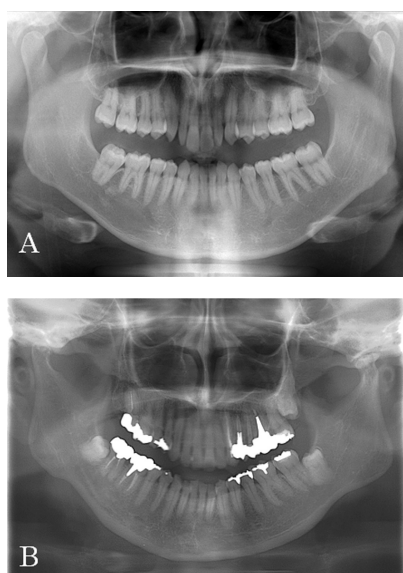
Panoramic radiograph of normal condylar head (A)
